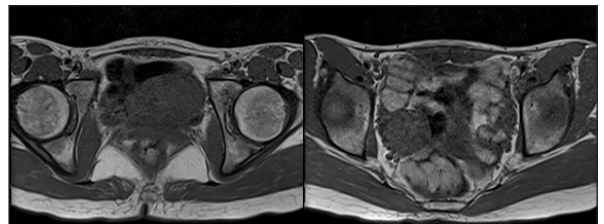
T1 Axial MRI Images Showing Hypointense Well-defined Lesion In Right Adnexa.
